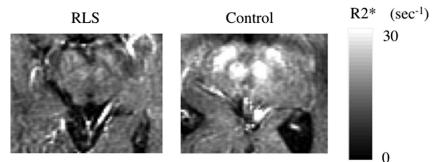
R2* images in a 70-year-old RLS patient and a 71-year-old control subject. Much lower R2* relaxation rates are apparent in the RLS case in both red nucleus and substantia nigra. (*Adapted from* Allen RP, Barker PB, Wehrl F, et al. MRI measurement of brain iron in patients with restless legs syndrome. Neurology 2001;56(2):263–5; with permission.)
